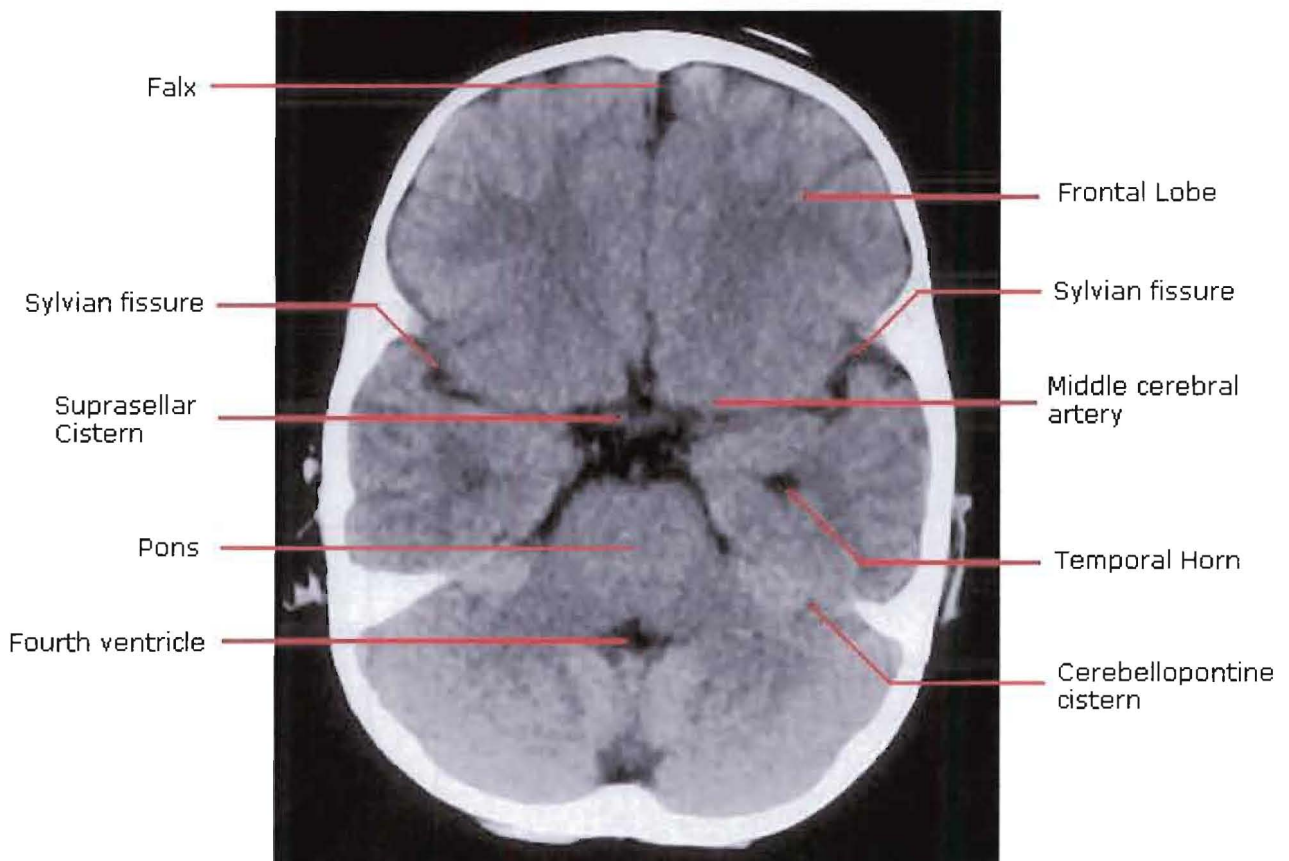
A CT image taken at the level of the fourth ventricle, highlighting certain anatomy of the brain relevant to TBM
